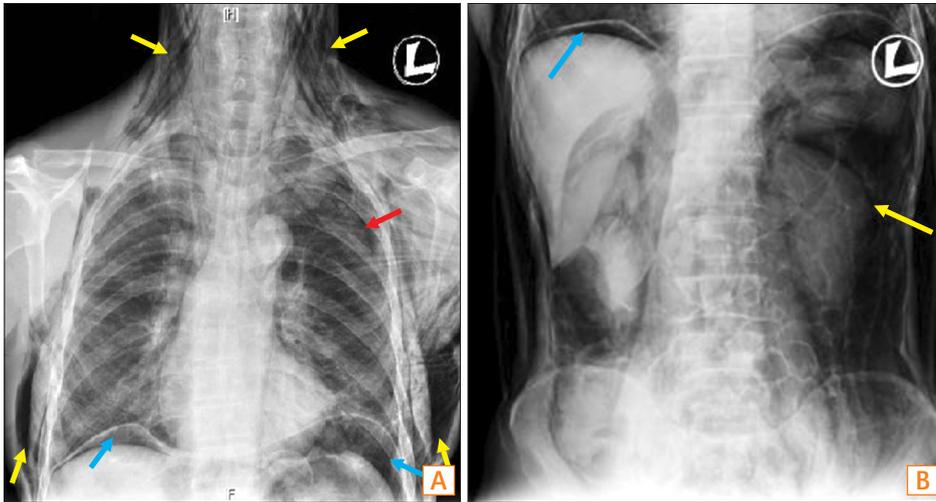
(A) Chest radiograph showing subcutaneous emphysema (yellow arrows), left pneumothorax (red arrow) and free air in intraperitoneum (blue arrows). (B) Abdomen radiograph showing pneumoretroperitoneum (yellow arrow) and pneumoperitoneum (blue arrow).
